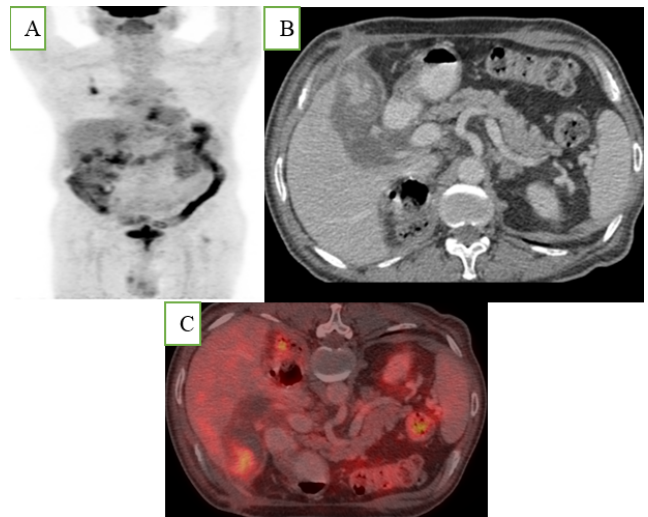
A: Maximum intensity projection image of FDG PET-CT showing focal tracer uptake in the abdomen on right side corresponding to lesion in body and fundus region of gallbladder (B) on axial CT section showing increased tracer uptake in the fused PET-CT image (C).
